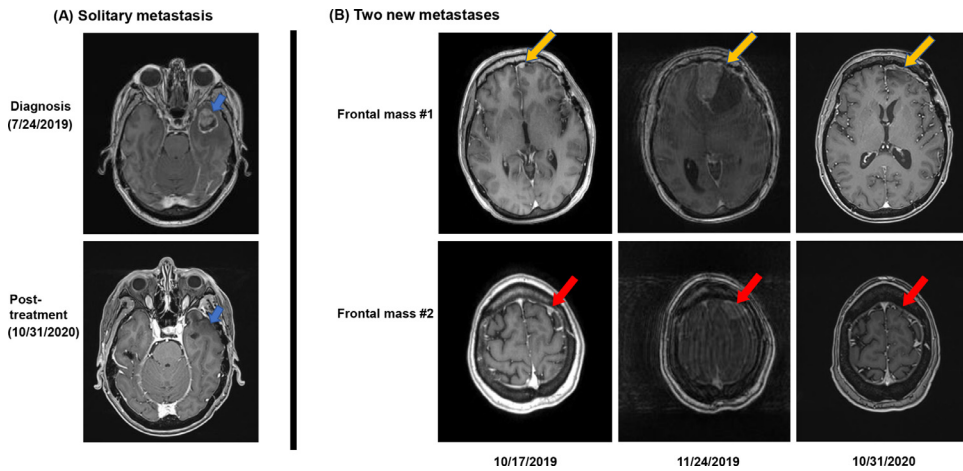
MRI images of the brain. (A) The initial solitary brain metastasis was resected on July 24, 2019, and the surgical cavity was subsequently treated with radiosurgery. (B) Two new leptomeningeal metastases with dural enhancement detected on brain MRI on October 17, 2019: an anterior left frontal metastasis (top panel, gold arrow) and a left frontal vertex metastasis (bottom panel, red arrow). These masses quickly progressed over a short period of time as demonstrated on the brain MRI scan on November 24, 2019. The patient underwent surgery for one of the two left frontal lesions and subsequently completed a course of whole brain radiation. As seen on the scan on October 31, 2020, all BMs continue to show no evidence of active disease, even the unresected left vertex metastasis. BM, brain metastasis.
